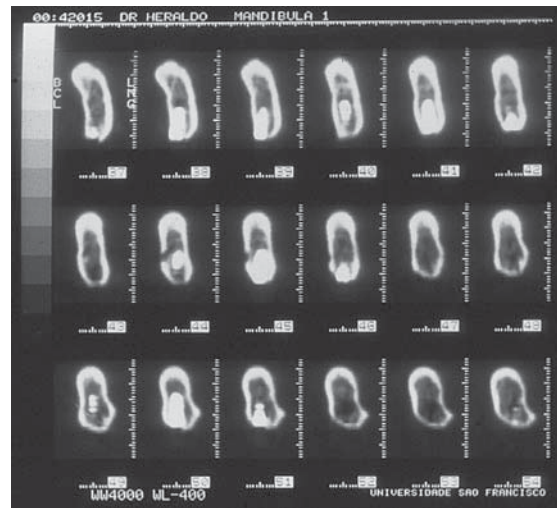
Reformatted oblique axial cuts of the mandibles (CT).
